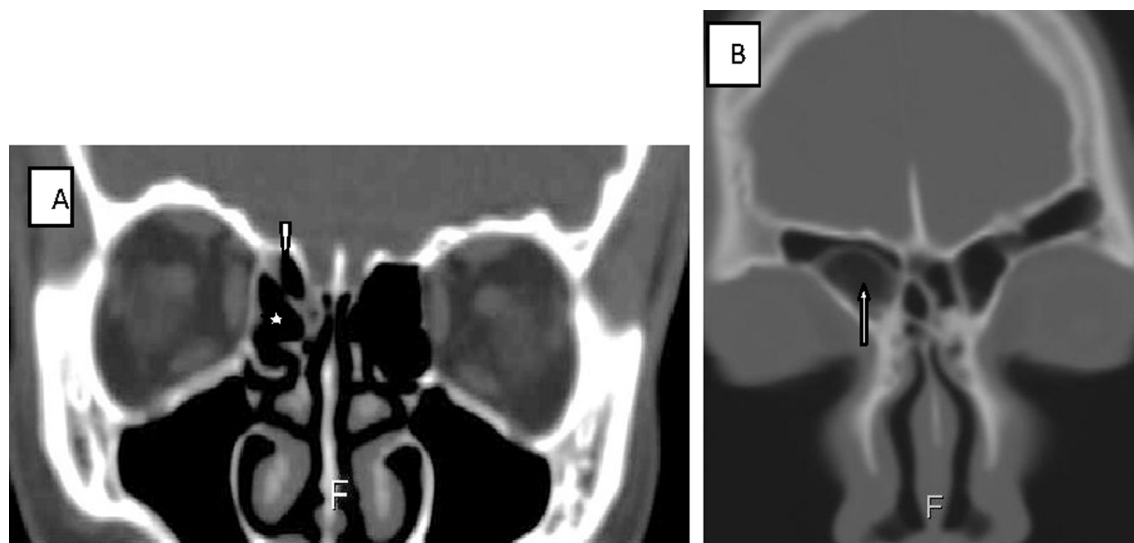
Coronal CT images (A) frontal cell (arrow head), agger nasi cell (star), (B) type 4 Frontal cell (arrow).
